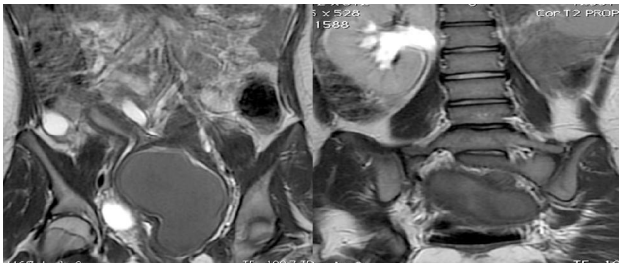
MRI T2 weighted Coronal Images: There is duplication of uterus with widely divergent corporal horns and separate cervixes and vagina representing Uterus didelphys. Hematocolpos with left renal agenesis is also noted. Findings are suggestive of OHVIRA syndrome (Obstructed hemivagina and ipsilateral renal anomaly)
